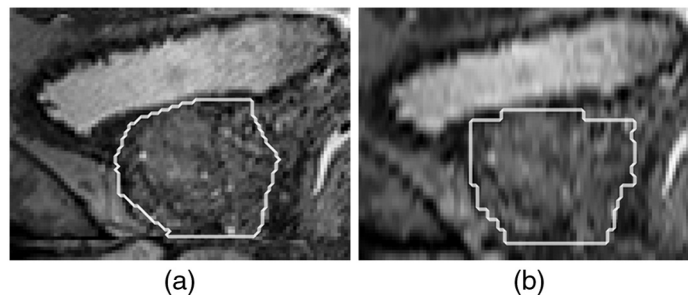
(a) Sagittal view of a 3D T2w MR image of the prostate and its segmentation by a radiologist (slice thickness: 1 mm). (b) Sagittal view of a 2D T2w MR image of the same prostate and its segmentation from the axial views by the same radiologist, resampled to the resolution of the 3D T2w MRI (original slice thickness: 3.25 mm).
